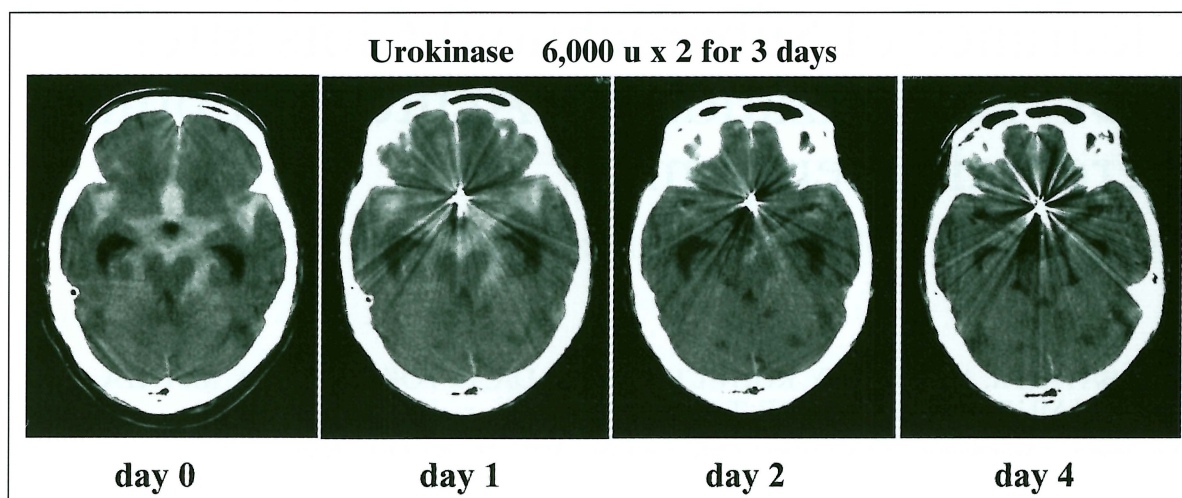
Serial CT scans of a representative case treated with GDC embolization.
